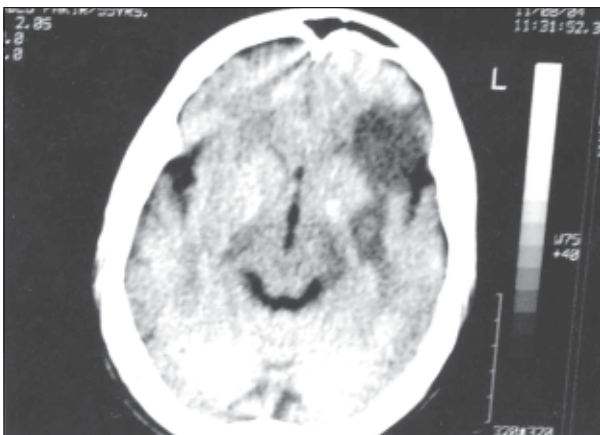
CT-Scan of brain showing large infarcts involving left frontal region at left ACA territory.
